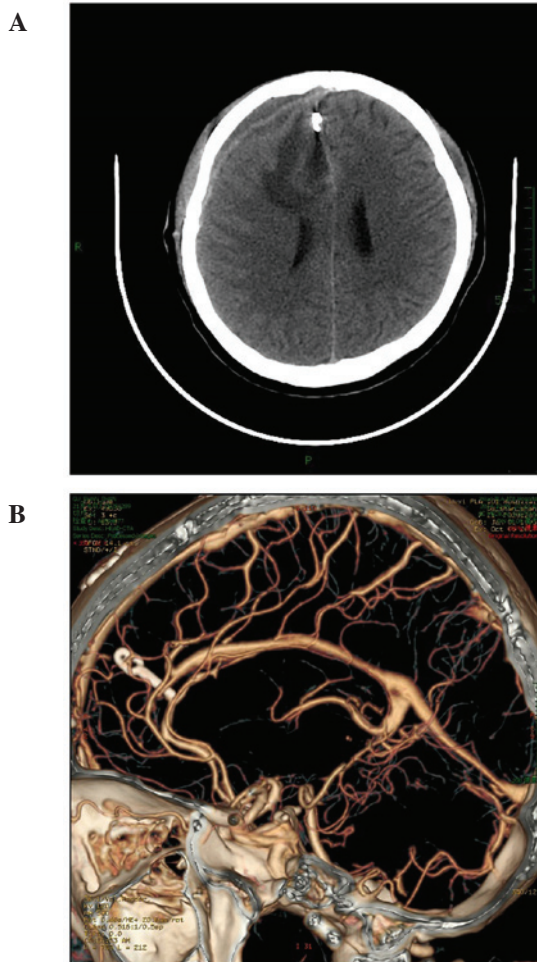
(A) Postoperative computed tomography (CT) scan showed that the hematoma and arteriovenous malformation had been completely removed. (B) Postoperative CT angiography demonstrated that the aneurysm had been clipped.
